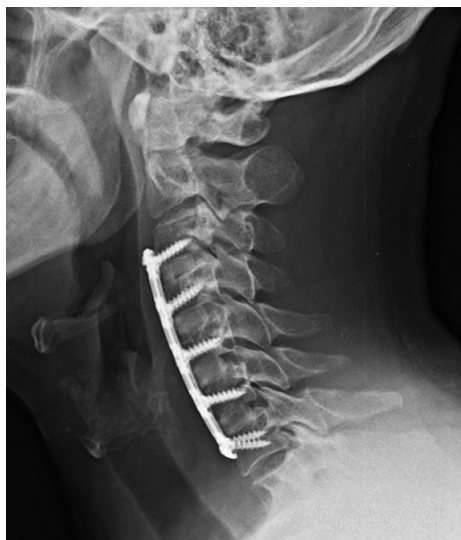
Three-month postoperative lateral radiograph of a 4-level anterior cervical discectomy and fusion utilizing allograft bone spacers and spanning titanium plate fixation. At 3 months, there is no evidence of graft subsidence and early graft incorporation is evident at the endplate interfaces.
